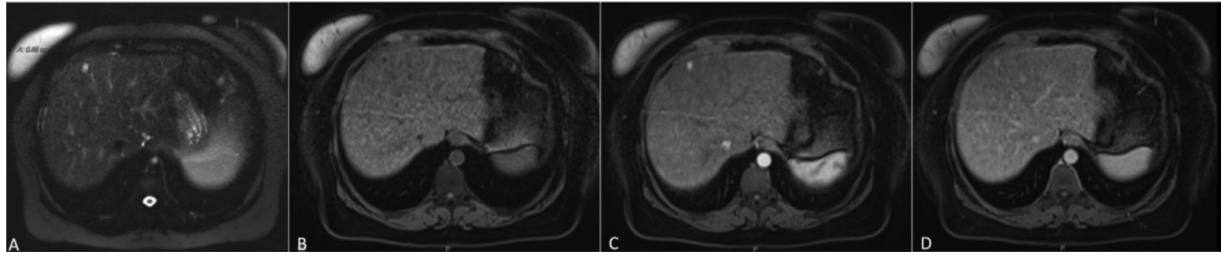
Initial MRI performed for HCC screening showing lesion in segment 4A (A) T2 fat-suppressed imaging demonstrating homogenous T2 hyperintense signal. (B) Precontrast imaging demonstrating T1 hypointense lesion with (C) avid arterial enhancement and (D) retention of contrast on equilibrium phase.
